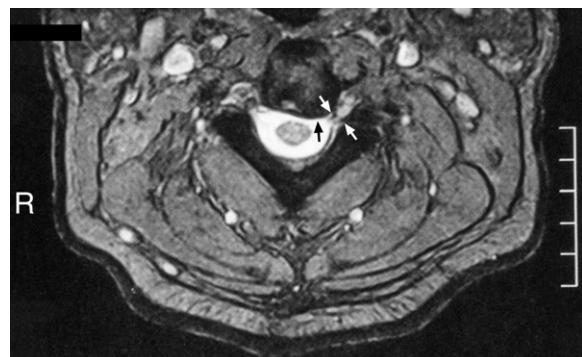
Cervical spine MRI T2-weighted axial image through the C2–3 intervertebral foraminae level. Note the left paracentral 'flattening of the thecal sac' (small black arrow). The antero-posterior dimension of the left intervertebral foramen is narrower (white arrows) when compared with the right side (R) of patient.
